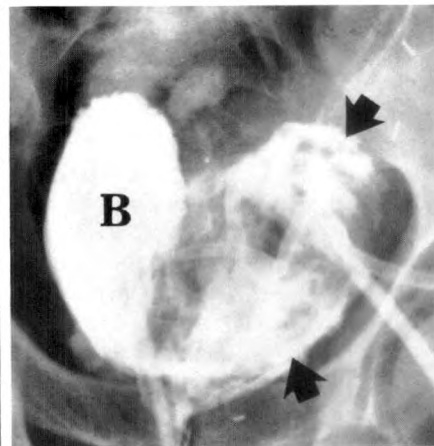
Radiograph of the pelvis made immediately after drainage with two sump catheters. Multiple large clots fill cavity (*arrows*). Communication with bladder (B) occurs at bladder neck.
